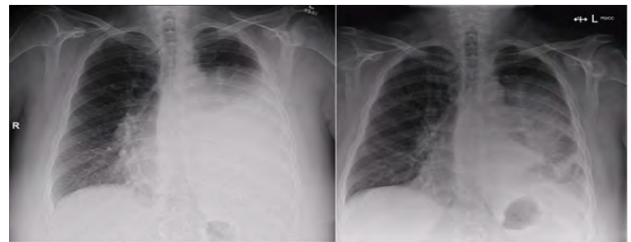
Presentation chest X-ray (left) demonstrating large pleural effusion prior to drainage and subsequent chest X-ray following intercostal catheter insertion.
